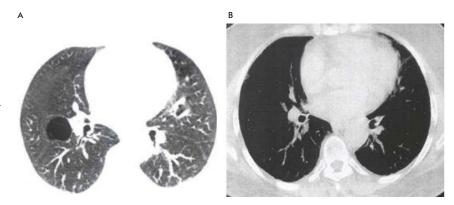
Imagenological improvement with IFN gamma treatment (HRCT of one patients is shown).
